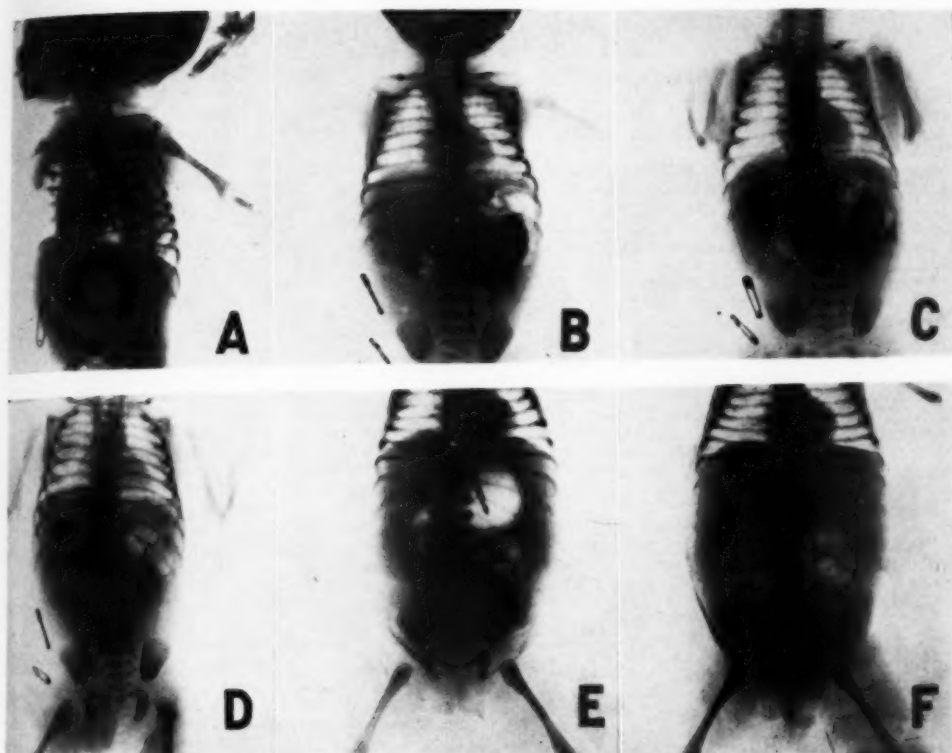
A. Roentgenogram of child five days old. Catheter in esophagus, air in stomach and duodenum, none in remainder of gastro-intestinal tract.
